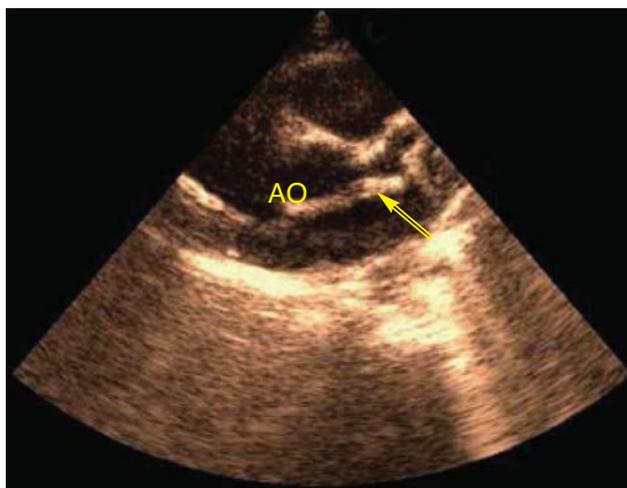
Two-dimensional echocardiography showing a giant aneurysm in the left main coronary artery
